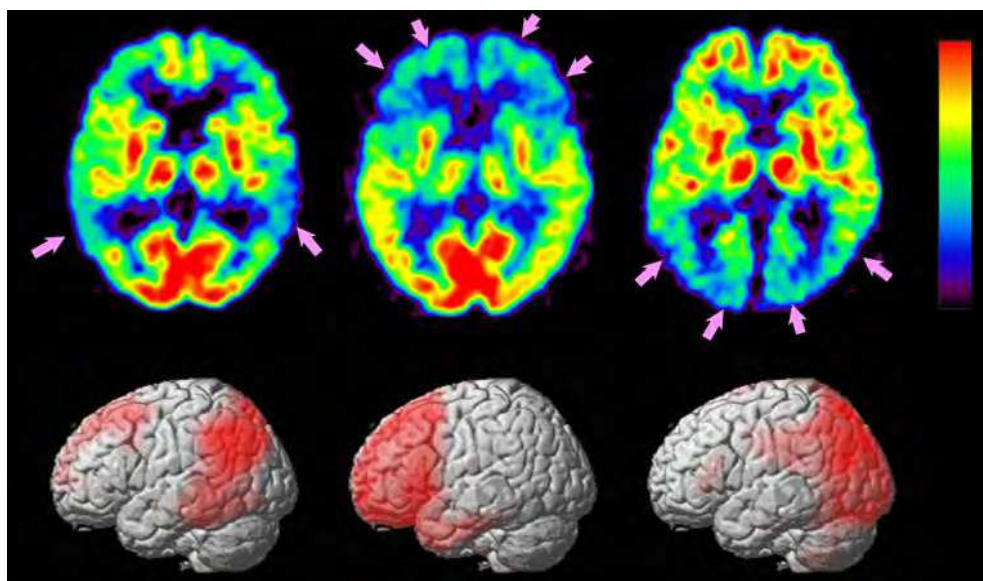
FDG-PET study of AD (left column), FTD (center column), and DLB (right column) using SPM. Compared to normal scans (upper row), SPM analysis (lower row) disclosed reduced glucose metabolic sites (arrows) clearly and showed the characteristic patterns of 3 major diseases with dementia.
